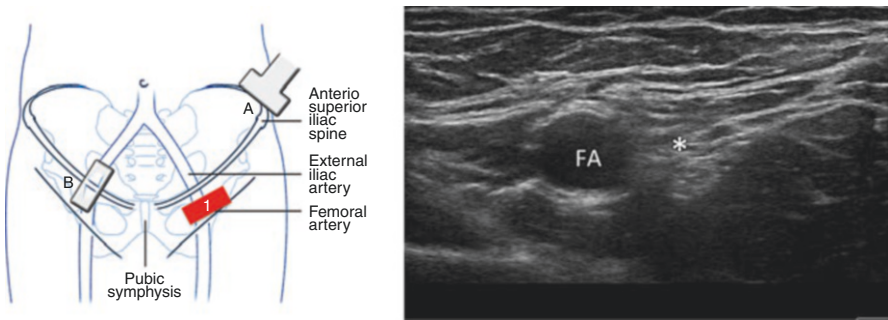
Figure showing the position of the ultrasound transducer (red square 1) and the corresponding sonography. FA femoral artery, * femoral nerve. (Reprinted with permission from Philip Peng Educational Series)
